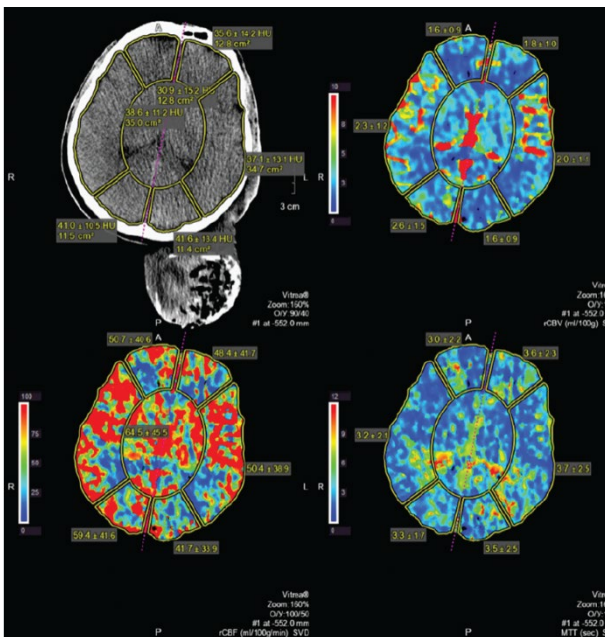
CT perfusionograms after endovascular stages in CBV (upper right), CBF (lower left) and MTT (lower right) modes. Perfusion parameters are within normal values, interhemispheric asymmetry is not noted
